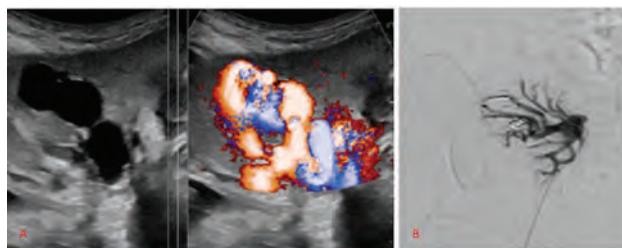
A - Ultrasound kidney transplant with doppler showing AVF; B - Post transplant arteriogram showing coil embolization
